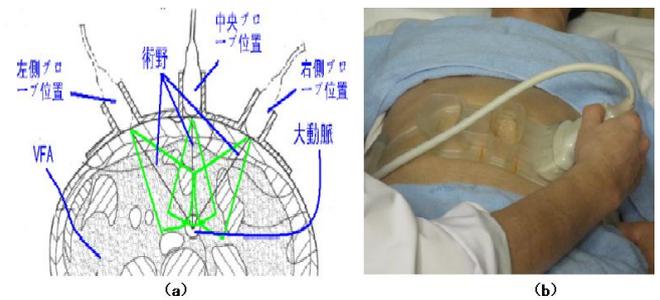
Ultrasound probe compatible device. The distance between two adjacent probe positions is 50mm, and the angle between two adjacent probes is 40° in unbent situation. (a) Diagnosis method for the belt-shaped device. (b) Clinical experiment for the belt-shaped device on a patient.
